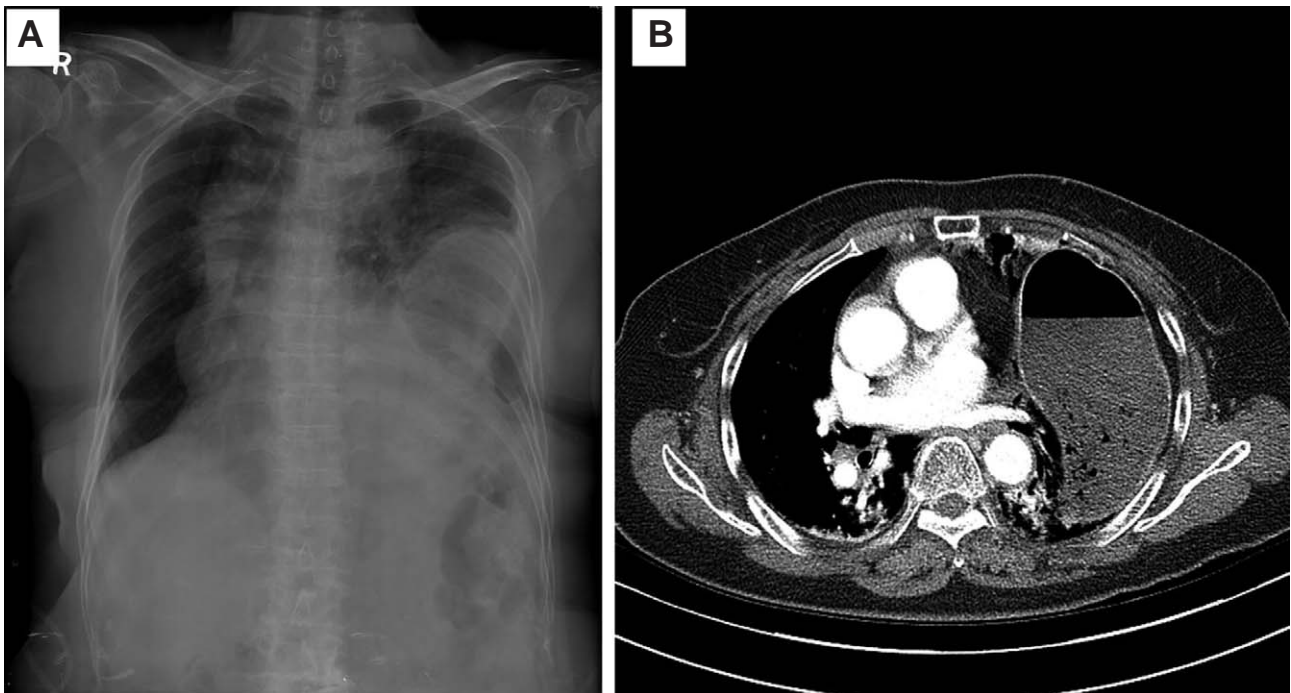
Left diaphragm injury at admission. (A) Simple Chest PA (B) Chest Computed Tomography.
